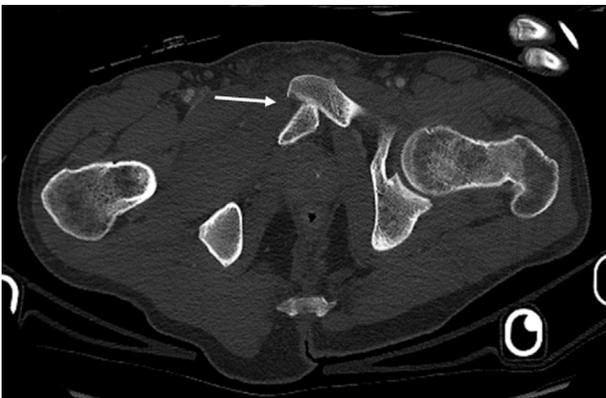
Axial CT of the pelvis in vertical shear injury: dislocation of pubic symphysis.
